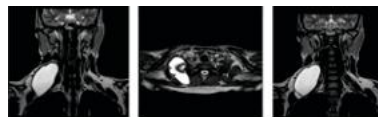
Coronal (A, C) and axial (B) magnetic resonance images showing a well-defined, T2-hyperintense cystic lesion in the right posterior cervical triangle extending inferiorly toward the supraclavicular fossa.
